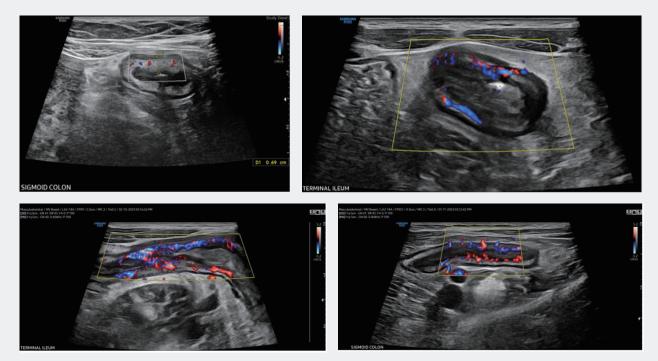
Assessment of Bowel Wall Hyperemia by color Doppler signal.
